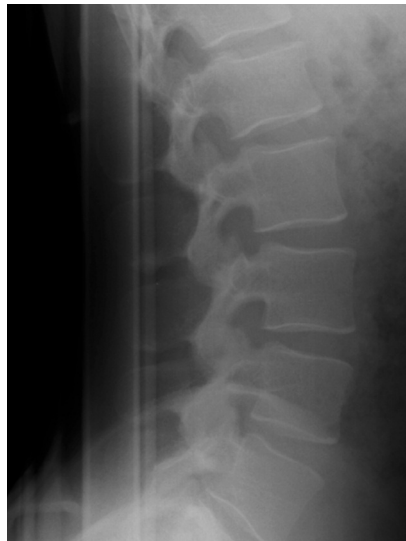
Lumbar spine X-ray, interpreted as indicating no significant lesions.
